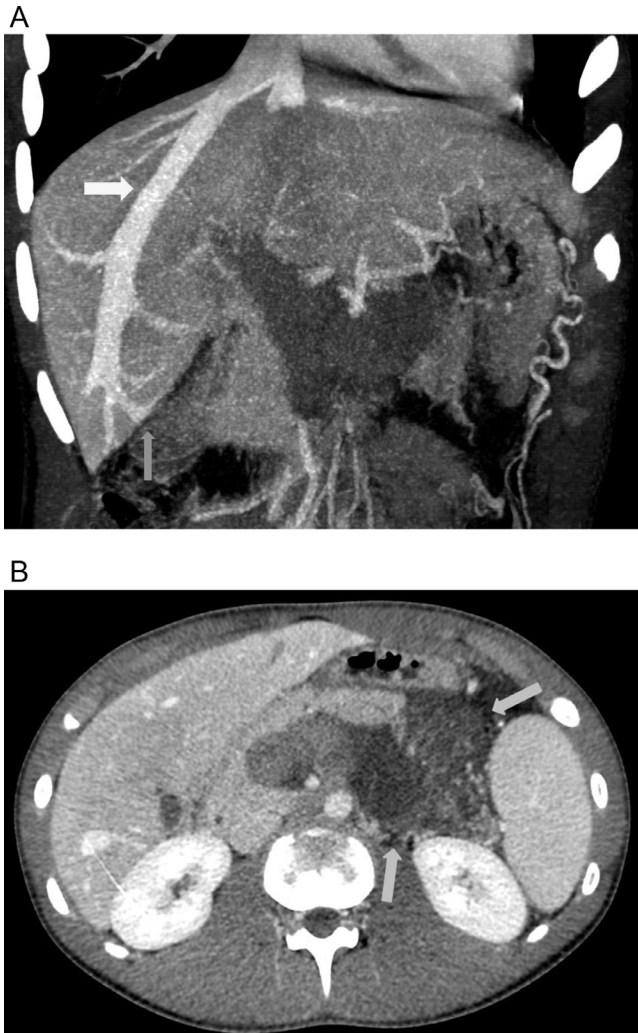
(A and B) Contrast-enhanced portal phase CT scan: The coronal oblique MIP (a) and the axial (b) images depicts: (A) vicariant activation of the capsular venous branches (blue arrow) with an enlarged right hepatic vein (yellow arrow); (B) large intra and extra-glandular fluid collections at pancreatic tail level (orange arrows) (Color version of the figure is available online.)
